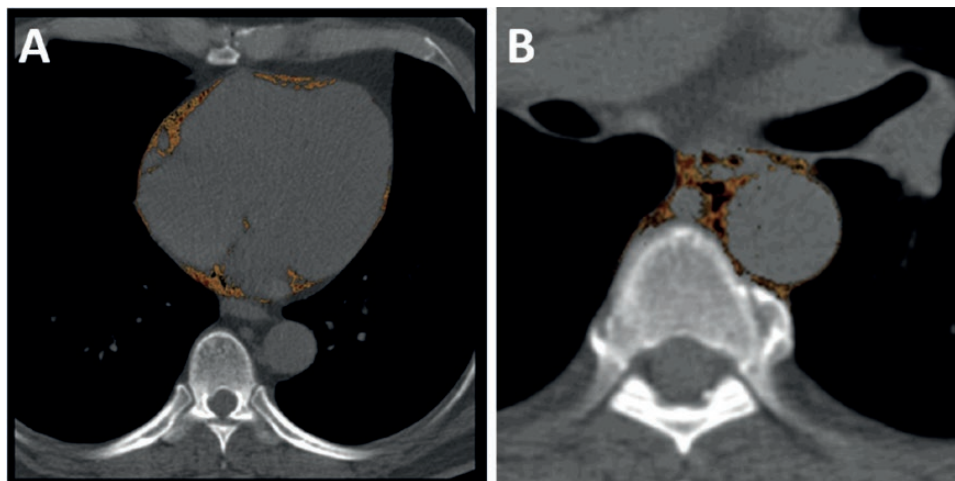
Multidetector computed tomography demonstrated pericardial and thoracic periaortic fat tissue measures. A, Pericardial adipose tissue: the fat between the heart and the pericardium. B, Thoracic periaortic adipose tissue: the fat surrounding the thoracic aorta (shown in axial view) [10]. Orange regions indicate visceral fat tissue.
